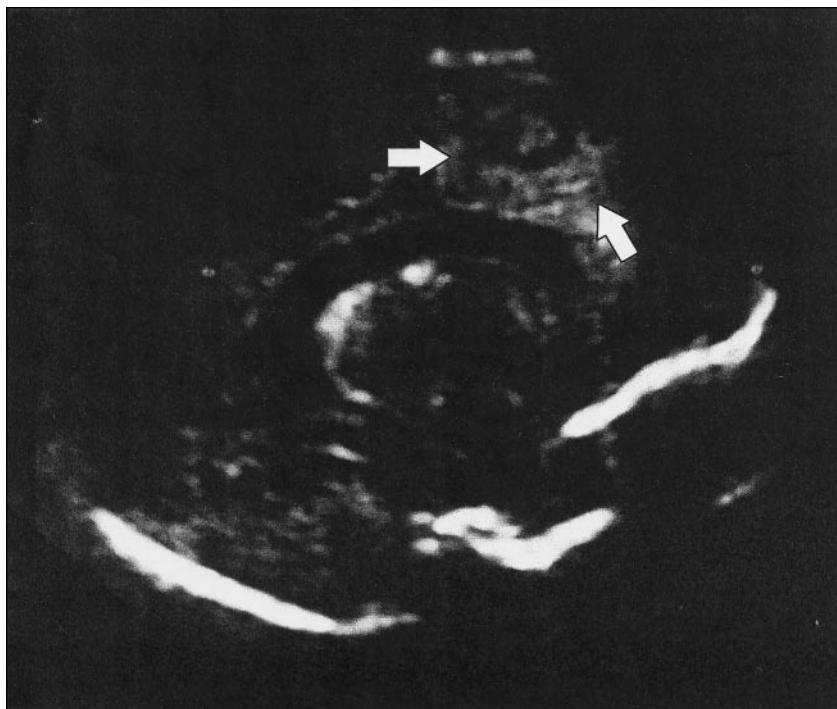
Cranial ultrasonography of late cerebritis, early abscess stage in a neonate (arrows).
